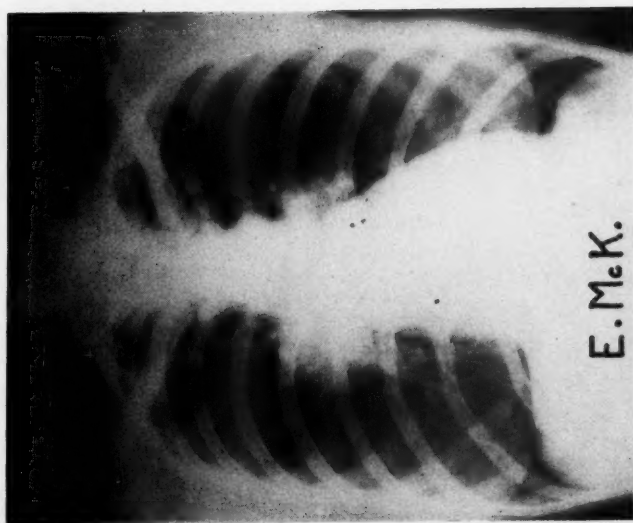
Roentgenogram showing circumscribed opacity in right hilum. Following pneumonectomy pathologic examination revealed tuberculoma.
